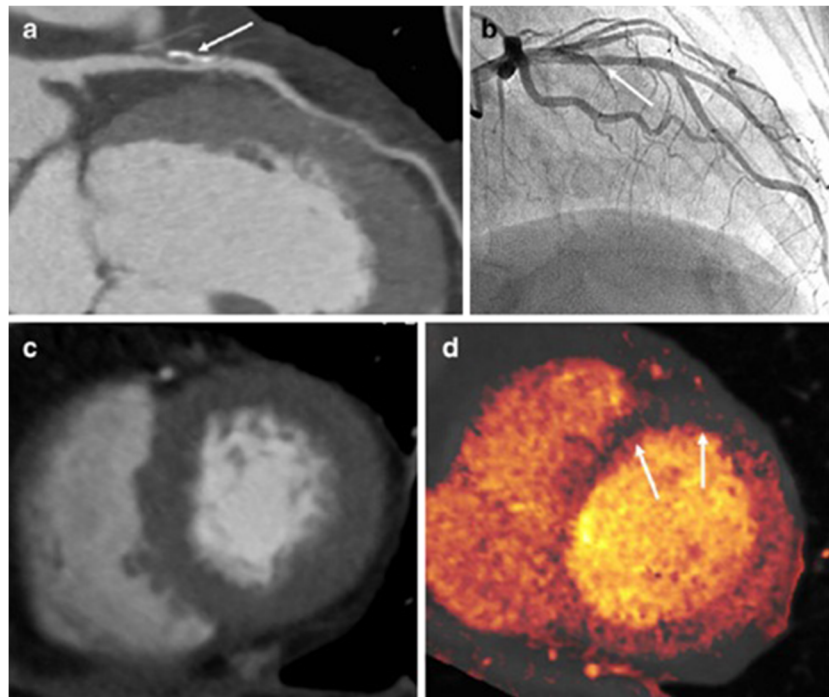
Images from a 66-year-old man with dyspnea and chest pain. a Coronary CT angiogram shows moderate stenosis with mixed calcified and noncalcified plaque in the proximal segment of the left anterior descending (LAD) coronary artery (*arrow*). b Conventional coronary angiogram does not reveal significant stenosis in the corresponding segment of the LAD artery (*arrow*). c The rest CT perfusion dual-source
